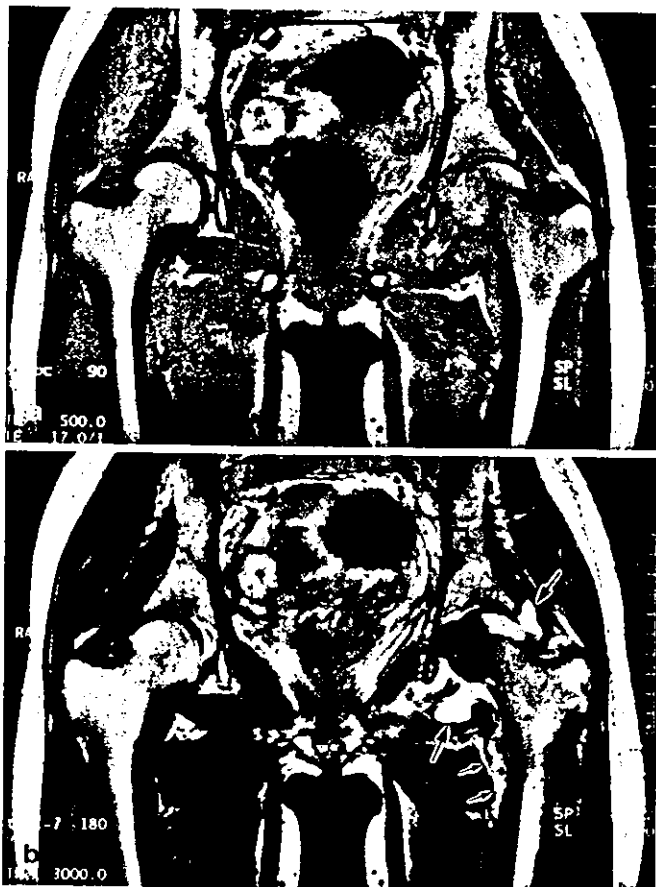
A Coronal T1- weighted image (TR/TE: 500/17) reveals a well-demarcated tumor with isointensity and bone-marrow edema showing low signal intensity in the intertrochanteric area (case no. 18). B Coronal T2-weighted image (TR/TE: 3000/96) reveals bone-marrow edema with high signal intensity in the corresponding area of T1-weighted image and obvious joint effusion (*large arrows*) and synovitis (*small arrows*) in affected side. The tumor shows low signal intensity
